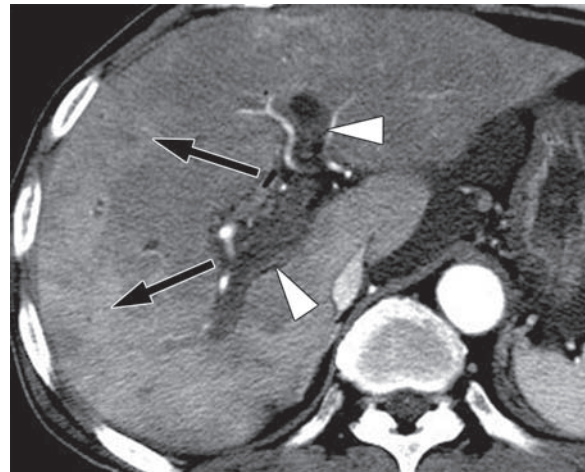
Portal vein thrombosis in a 60-year-old man who had undergone surgery for common bile duct cancer 5 months earlier. Arterial phase CT scan shows thrombosis of the right and left portal veins (arrowheads) and enhancement of the periphery of the right hepatic lobe (arrows) secondary to the compensatory increase in arterial flow.
